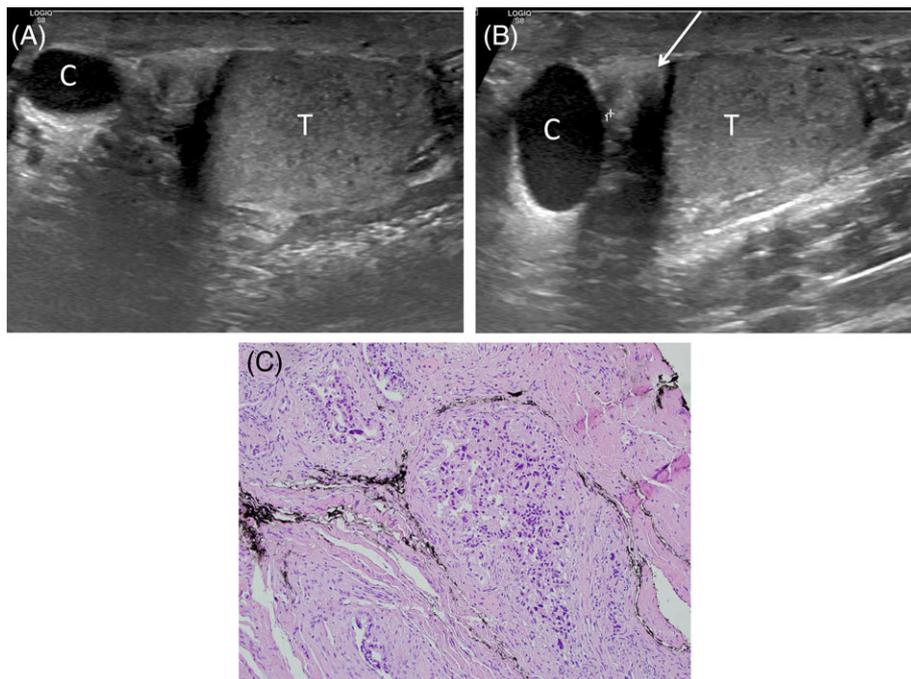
A 65-year-old male with adenomatoid tumor. A, Sagittal sonogram of the epididymal head shows the cyst (C) and testis (T). B, Sonogram obtained during palpation with the probe placed on top of the palpated lesion shows a 7-mm echogenic nodule (arrow). C, Pathology revealed an adenomatoid tumor
